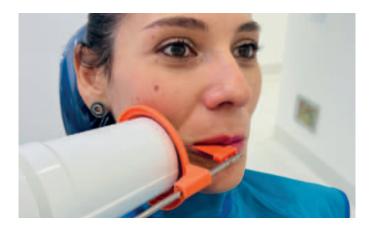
Correct positioning of the centering device and the X-ray tube.
